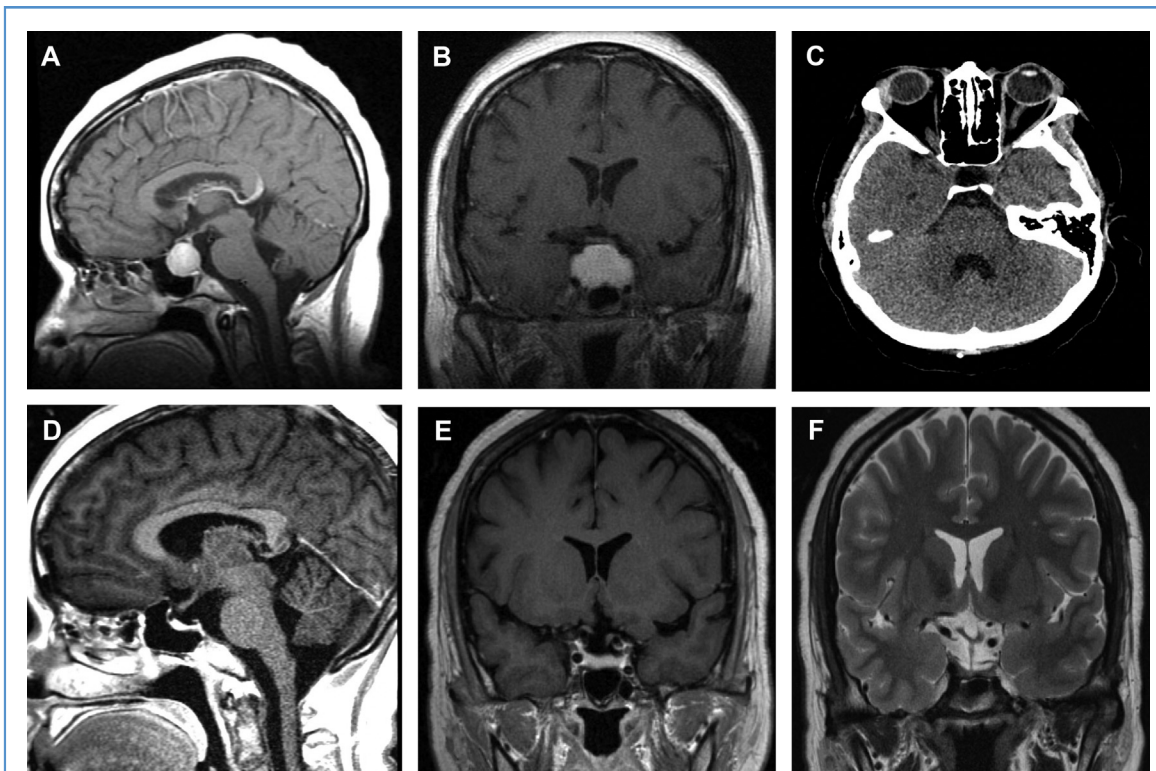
(A and B) Sagittal and coronal plane reformats of magnetic resonance imaging (MRI) brain T1 sequence with gadolinium contrast revealing a large enhancing mass in the sella turcica with Knosp 3A cavernous sinus invasion bilaterally. The mass is avidly enhancing and abuts the optic chiasm. The imaging is most consistent with a pituitary adenoma. (C) Computed tomography of the head without contrast reveals hypodensity within an enlarged sella turcica. The previously
